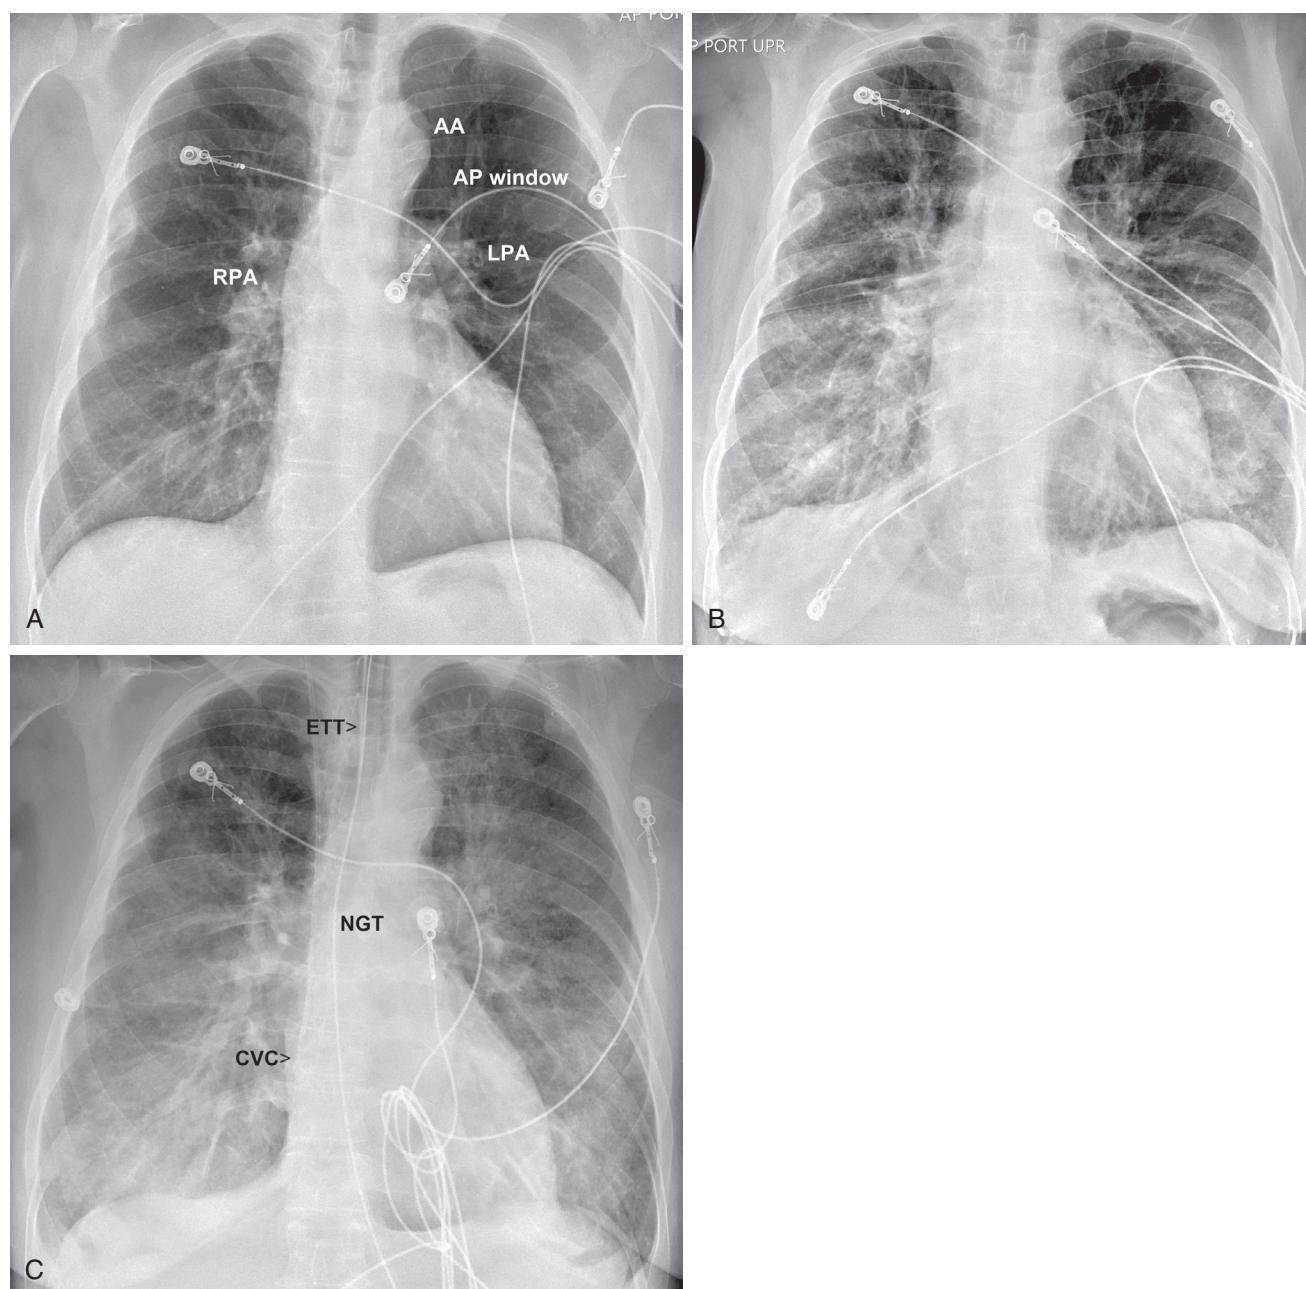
■ A, Anteroposterior (AP) upright chest x-ray. Emphysema is evidenced by hyperexpansion and attenuation of the upper lobe pulmonary arteries and veins. AA, aortic arch; AP window, aortopulmonary window; LPA, left pulmonary artery; RPA, right pulmonary artery. B, Anteroposterior (AP) upright chest x-ray: +3½ hours. Same patient 3½ hours later with redistribution of the pulmonary vasculature to the upper lobes, interstitial pulmonary edema as evidenced by indistinctness of the pulmonary vessels and “peribronchial cuffing,” a small right pleural effusion, and developing cardiomegaly. C, Anteroposterior (AP) supine chest x-ray: +4½ additional hours. Same patient 4½ hours later with diffuse but symmetric airspace opacities consistent with fluid filling the alveoli. Increasing pleural effusions are now layering posteriorly, giving a “whiter” appearance to the mid and lower hemithoraces. CVC, right internal jugular vein central venous catheter; ETT, endotracheal tube; NGT, nasogastric tube.
